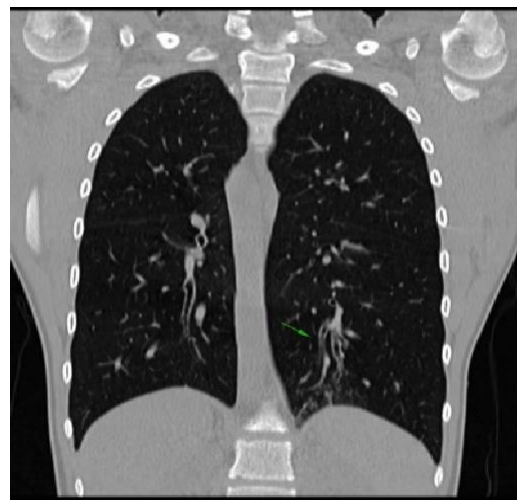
Left lower lobe bronchiectases on CT scan (coronal reconstruction).
